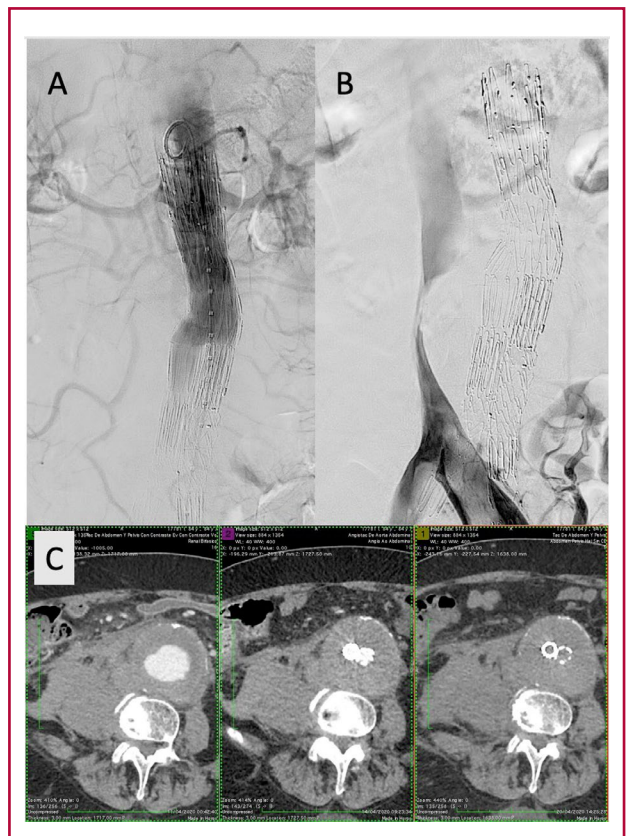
Patient with inferior vena cava compression due to retroperitoneal hematoma. A, aneurysm exclusion, B venography with thrombi in both iliac veins, C follow-up computed tomography of the aneurysm with aneurysmal sac exclusion
